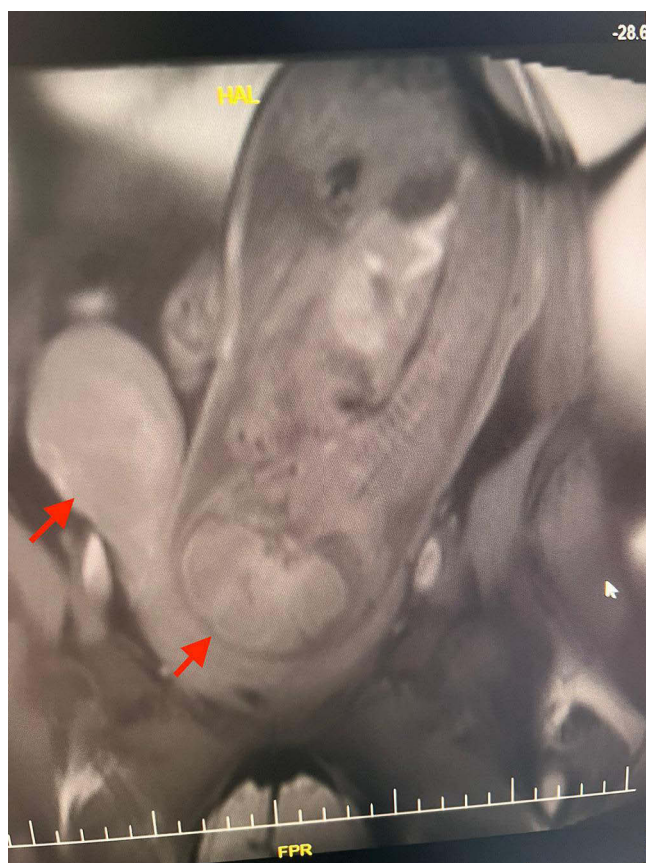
Magnetic resonance image showing two adjacent noncommunicating uteri (arrows), one of which is empty and the other is bearing a fetus.
